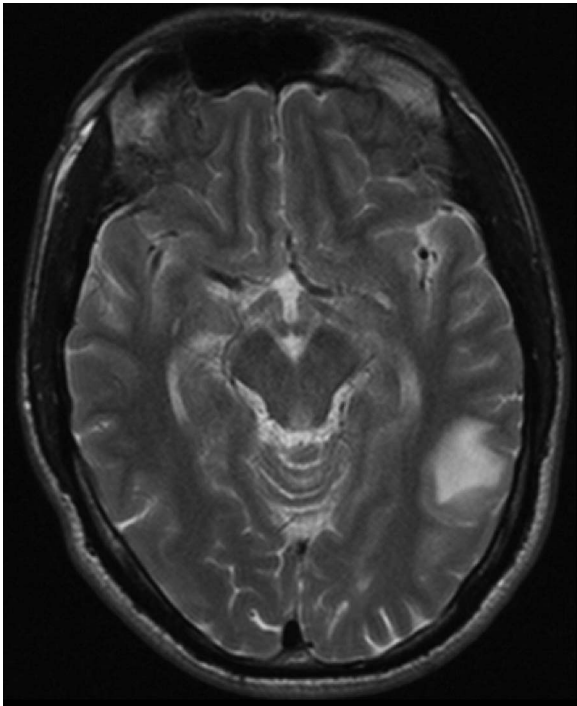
Brain MRI 1 October: mass lesion measuring 28×20×22 mm in the left parietal lobe.
